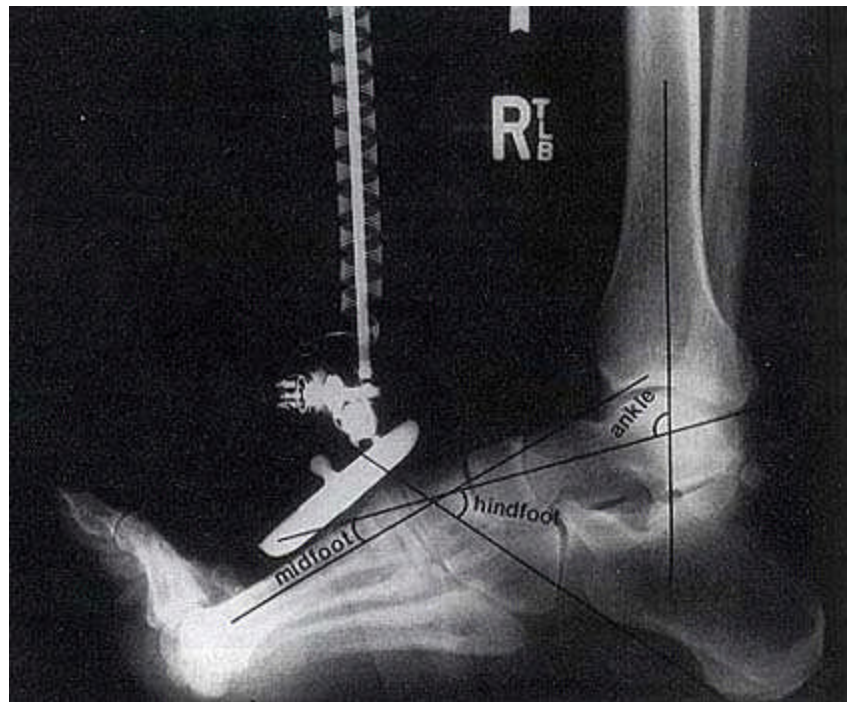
A lateral radiograph demonstrates 1) technique for making angular measurements of the ankle, hindfoot and midfoot, and 2) simultaneous positioning of the electrogoniometer.
